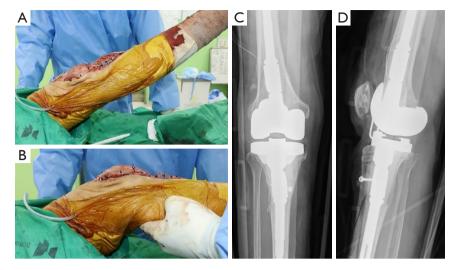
Postoperative range of motion and radiographs. (A,B) Postoperative range of motion (0–30 degrees). (C,D) Postoperative knee radiographs.
